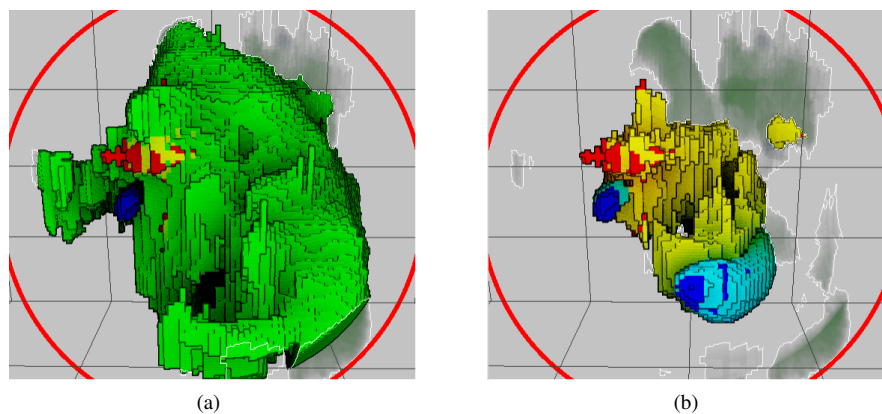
The tumor intersection closeup. The region where only the T2-weighted MRI modality is active (green) occludes other segments (a). By deselecting it (b), the underlying STR configuration can be made visible. In this case, relatively large areas are displayed where the T2-weighted MRI and the T1-weighted MRI modality (yellow) as well as the T2-weighted MR and the PET modality (turquoise) are active. Note that contours and ambient occlusion convey the shape of the regions well.
